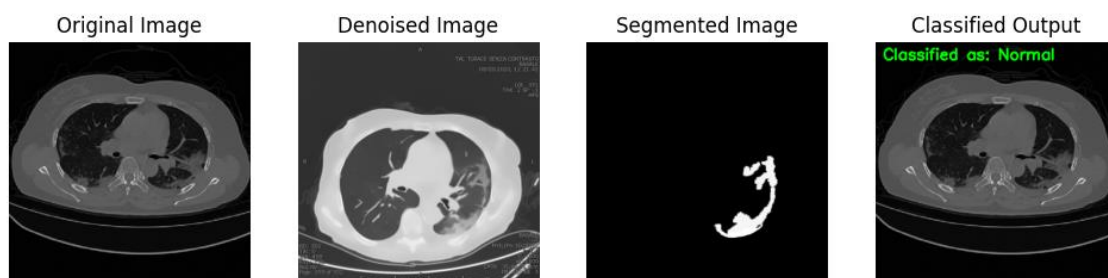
Predicted Outcome as non-COVID-19 by Proposed CT-CXR-Net.
